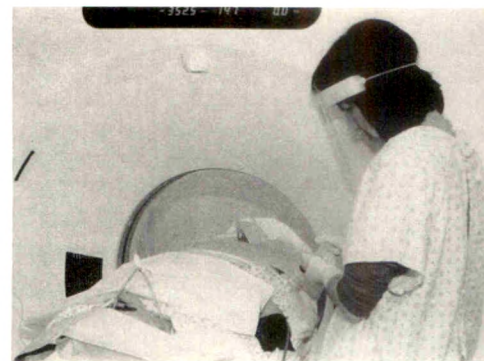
Fine-needle aspiration biopsy with CT guidance. Risk-reduction measures include use of transparent face shield, gloves, gown, and sharp-instrument precautions.
